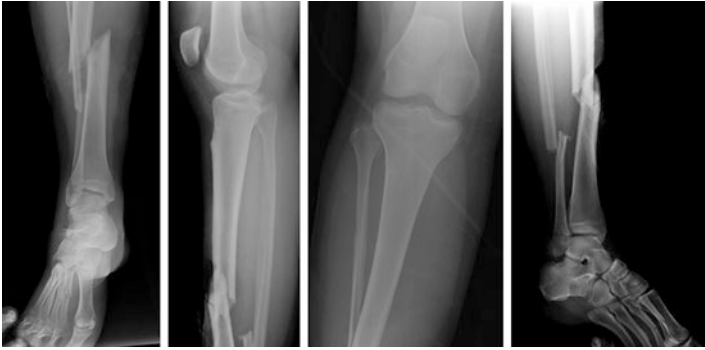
AP and lateral injury radiographs of the right tibia and right foot
